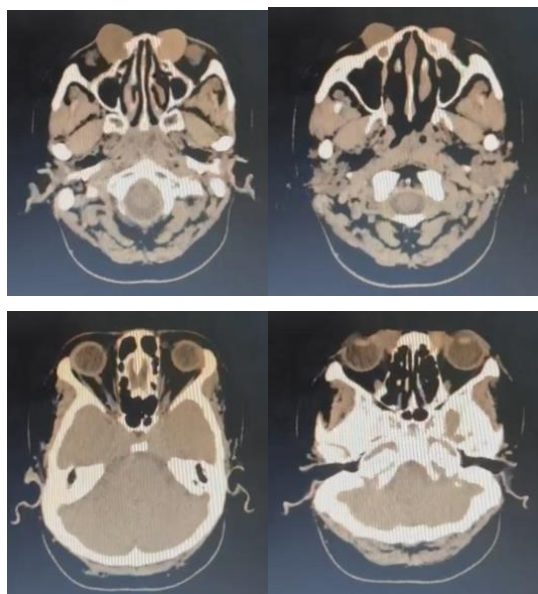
CT scan of the orbits with contrast
